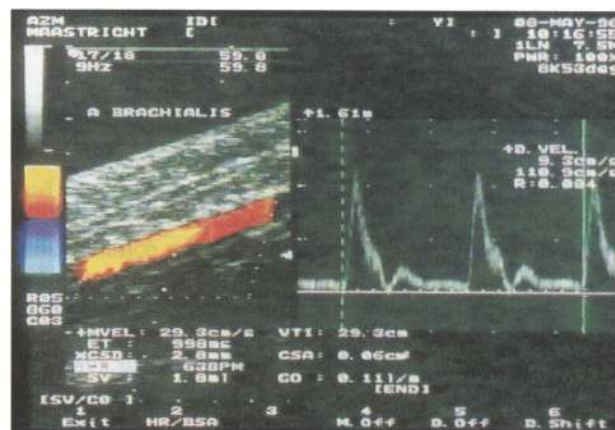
Colour Duplex scan of the brachial artery at the elbow. The B-mode image (left-hand site) shows the artery, and a Doppler spectrum is obtained from the same vessel (right-hand site). From the cross-sectional area and mean velocity, the volume flow has been calculated. (0.11 l/min).
